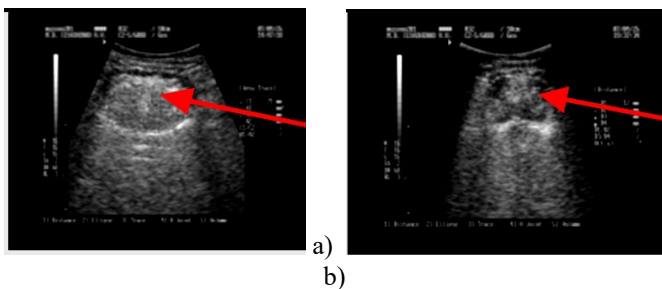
a) Visualization of a hypertrophied lingual tonsil during ultrasound examination prior to cryosurgical intervention - tissue is defined without clear boundaries, round in shape, relatively homogeneous, located among the characteristic and easily recognizable landmarks of the oral cavity and pharynx. b) Ultrasound scanning 30 days after cryodestruction of the lingual tonsil. The lingual tonsil is reduced in volume
